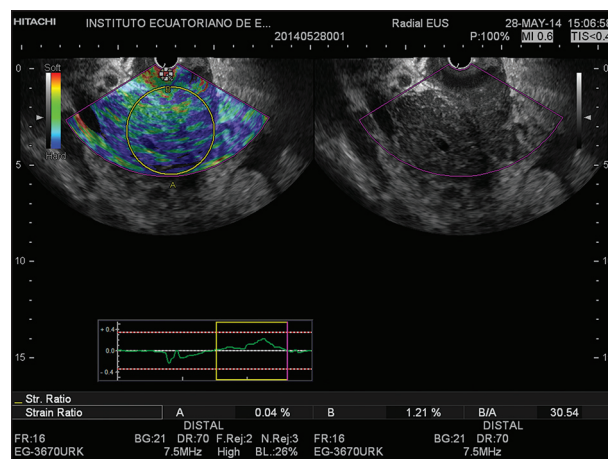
Endoscopic ultrasonography elastography showing the heterogeneous mass in the head of the pancreas (Strain Ratio: 30)
